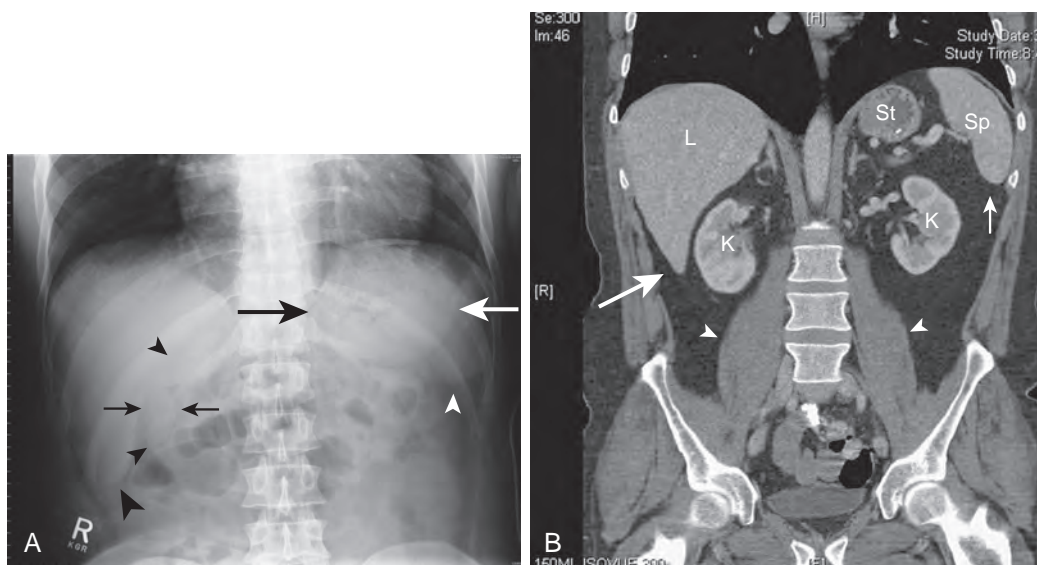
Gallbladder, liver, spleen, and stomach. A. Supine abdominal radiograph shows the gallbladder (small black arrows), hepatic angle (large black arrowhead), splenic tip (white arrowhead), and stomach (large black and white arrows). Note the partially visualized right kidney (small black arrowheads). B. Coronal CT scan of the abdomen shows the hepatic angle (large arrow) outlined by perirenal fat, splenic tip (small arrow), psoas muscles (arrowheads), and kidneys. L, liver; K, kidney; Sp, spleen; St, stomach.
